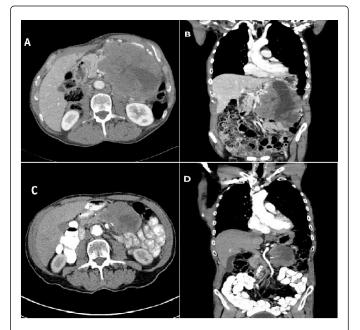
CT scan from May of 2011 showed an enlargement of the mesenteric mass to 12.9\*10.2\*20.3 cm (figure 2A, axial view, figure 2B, coronal view). CT scan from February 2012 showed decrease in tumor size, measured after treatment 7.2\*7.6\*9.1 cm (figure 2C, axial view, figure 2D, coronal view).
